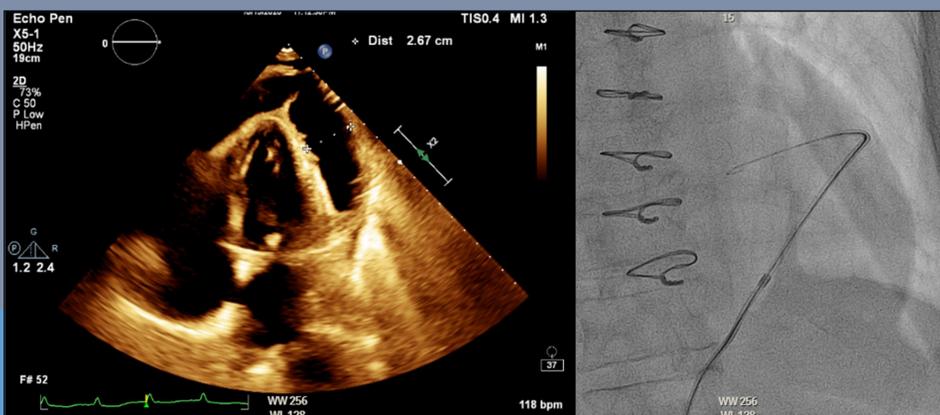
Transthoracic echocardiography (apical 4 chamber) showing large pericardial effusion with tamponade physiology (LEFT). Pericardiocentesis with insertion of pericardial drain under fluroscopy (RIGHT).
